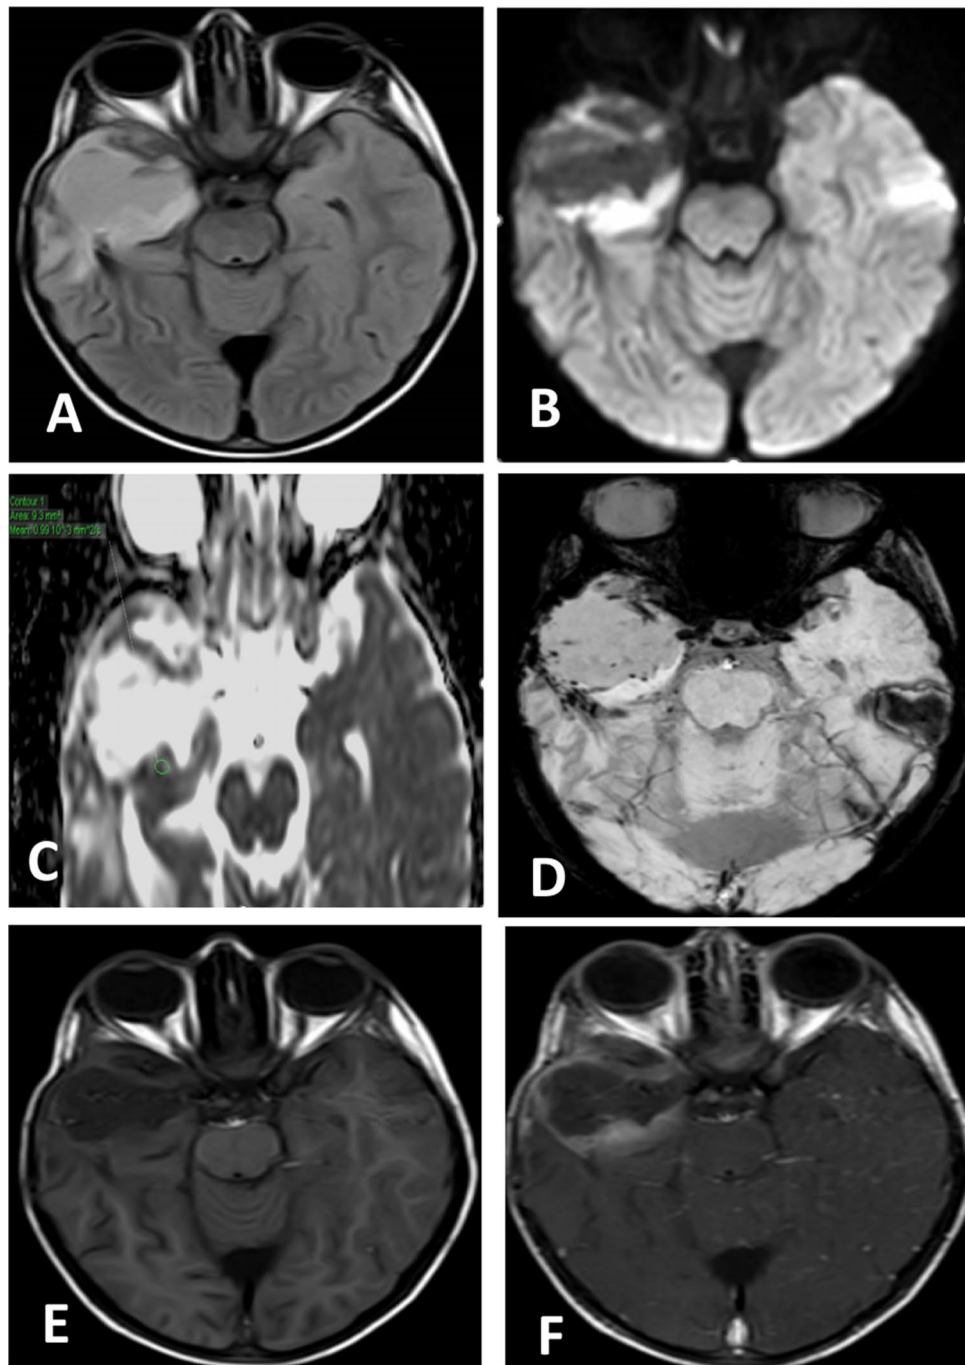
Twelve-year-old female children presenting with anaplastic astrocytoma. A Axial FLAIR shows right temporal space-occupying lesion of intermediate signal. B Axial DWI and C ADC show diffusion restriction with low ADC value measuring $0.99 \times 10^{-3} \text{ mm}^2/\text{s}$. D SWI shows prominent vascularity with more than 10 foci of hypointense signal (ITSS score 2). E Axial T1WI shows low signal mass. F Axial post-contrast T1WI shows peripheral enhancement
